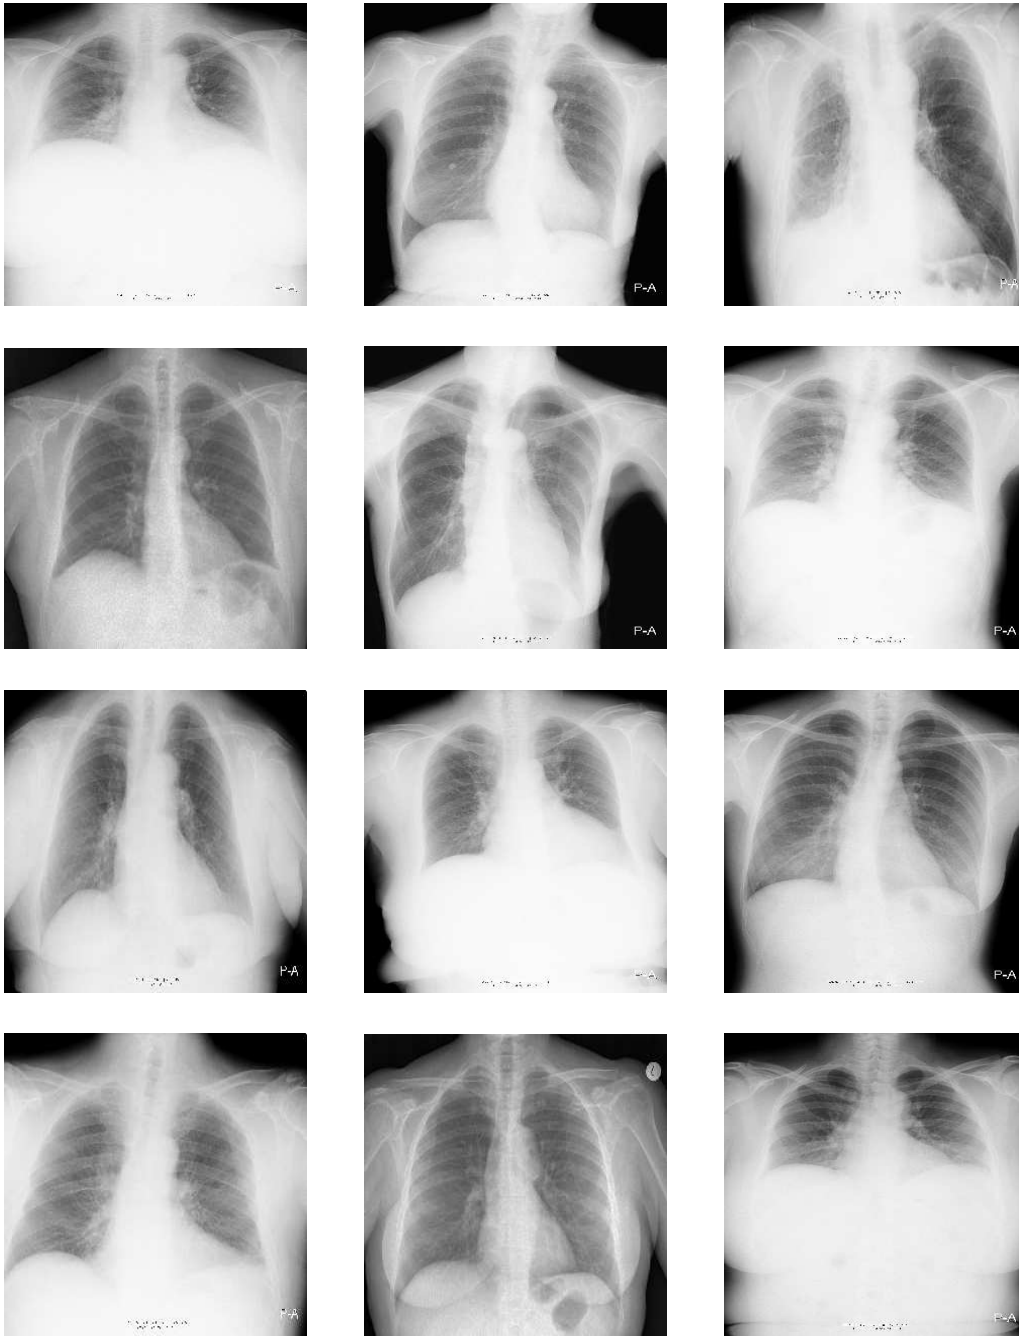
examples of chest radiographs in the Niguarda Database*
